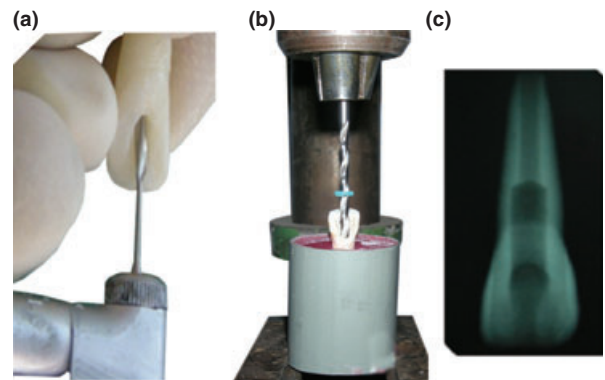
Immature tooth model preparation (a) Instrumentation with Peeso reamers. (b) Engineering twist drill of 3 mm diameter to extend the preparation of the canal. (c) Radiograph showing finished immature tooth model.
